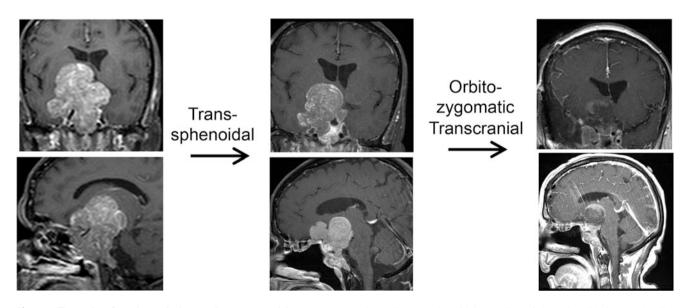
Example of a giant pituitary adenoma requiring a twostaged approach. Shown is an example of a giant nonfunctional pituitary macroadenoma in a patient with two decades of vision loss. MRI revealed tumor eroding into the right Sylvian fissure with significant inferior extension into the sphenoid sinus. A staged approach was performed, with an
